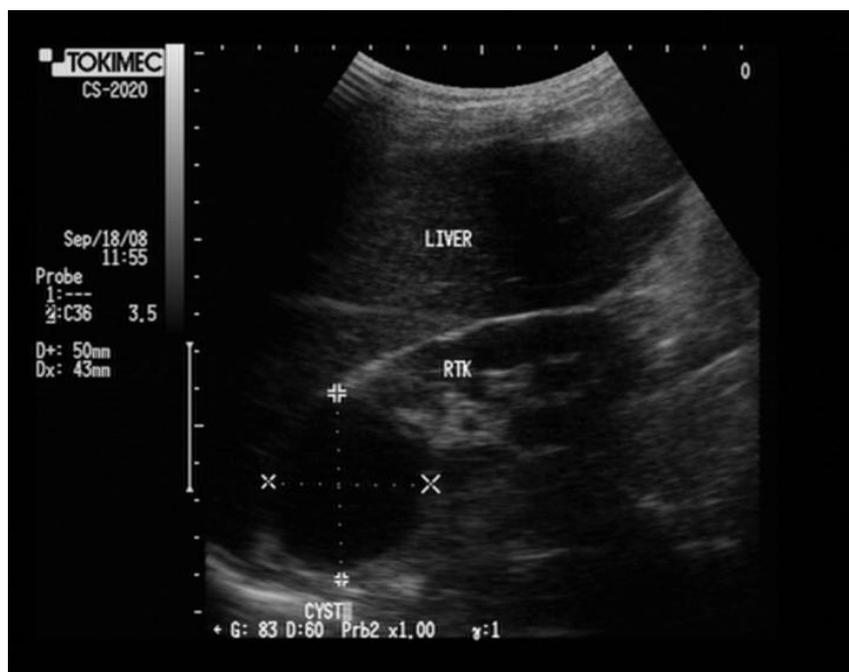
Longitudinal renal sonogram in TB patients; upper polar simple renal cyst
